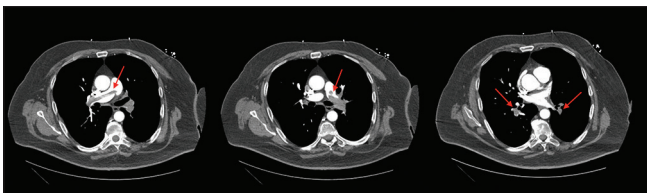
Contrast-enhanced computed tomography angiogram demonstrates a large saddle pulmonary embolism extending bilaterally into subsequent lobar and segmental pulmonary arteries
